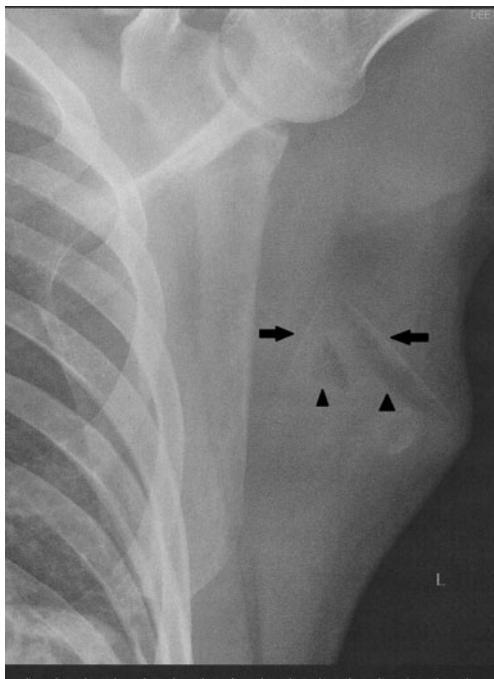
Frontal radiograph of left upper thorax showing an obvious soft tissue mass with several radio-opaque triangular foreign bodies within the left subcutaneous region and latissimus dorsi muscle (arrows). Gas was apparent within portions of the foreign bodies (arrowheads). No bone involvement was evident
